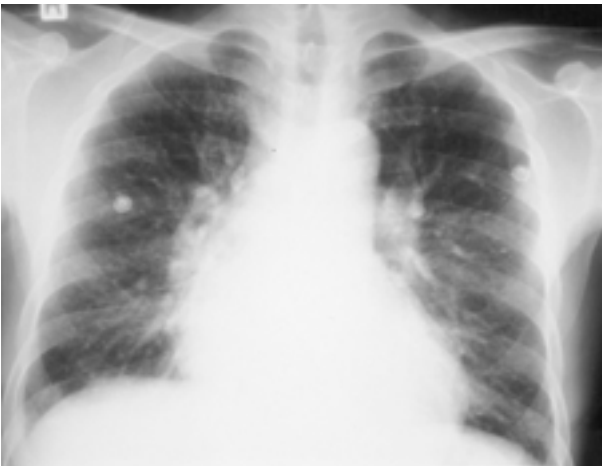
Posteroanterior chest radiograph shows cardiomegaly with increased pulmonary vascularity, suggesting congestive heart failure.
